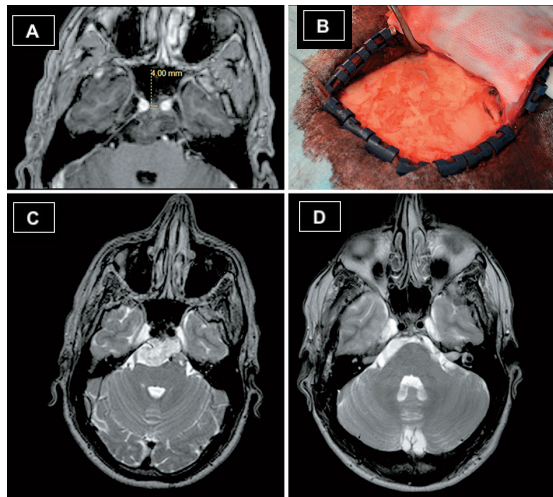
A) Preoperative axial MR T1-weighted image with gadolinium showing a clivus chordoma arising from the midline and displacing posteriorly the brainstem. The para-clival inter-carotid distance is around 4 mm. Due to the short ICA-ICA distance we decided to perform a one-stage sub-temporal trans-tentorial approach. B) Intraoperative view of the temporal bone exposure, from the zygomatic arch root anteriorly to the asterion posteriorly. C) Preoperative axial MR T2-weighted image showing the clivus chordoma extending in the pre-pontine cistern and totally behind the two ICAs. D) Postoperative axial MR T2-weighted image showing gross total tumor removal [adapted from La Corte et al., 2018].
